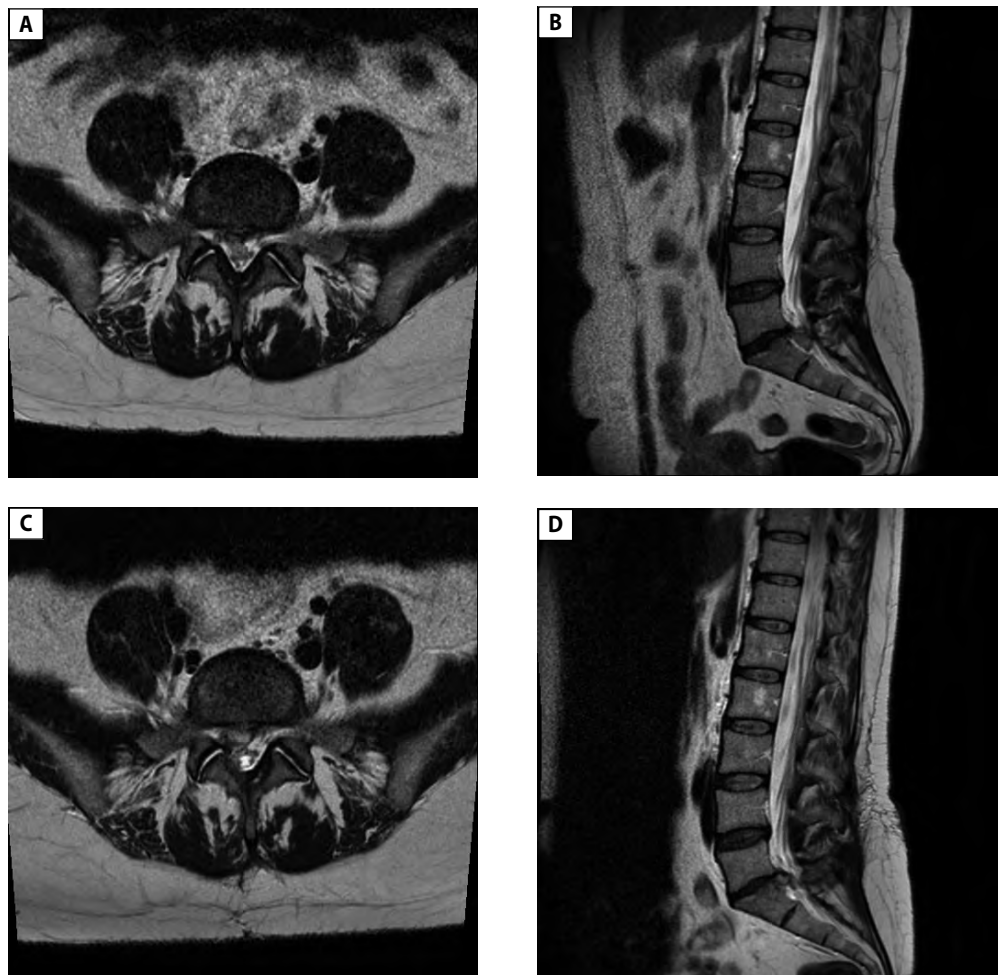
Axial (A) and sagittal (B) magnetic resonance images show large left disc sequestration at level of L5/S1. Postoperative axial (C) and sagittal (D) magnetic resonance images depict recurrent herniated disc two months after right-sided microdiscectomy
